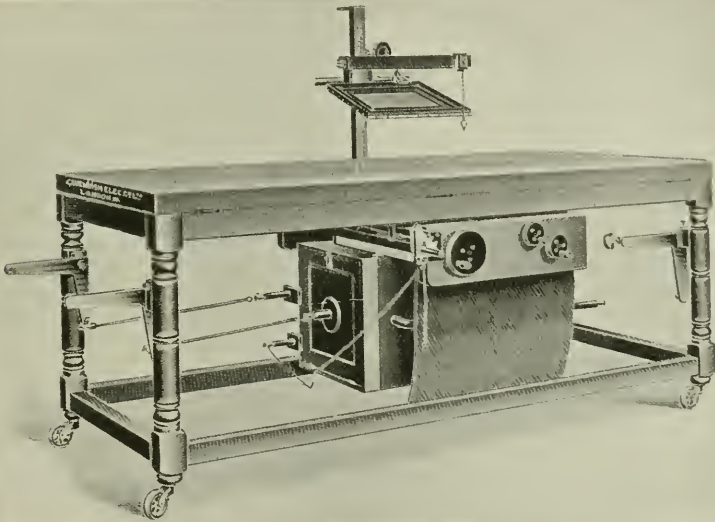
Cavendish universal X-ray couch. (Cavendish Electrical Co.)
